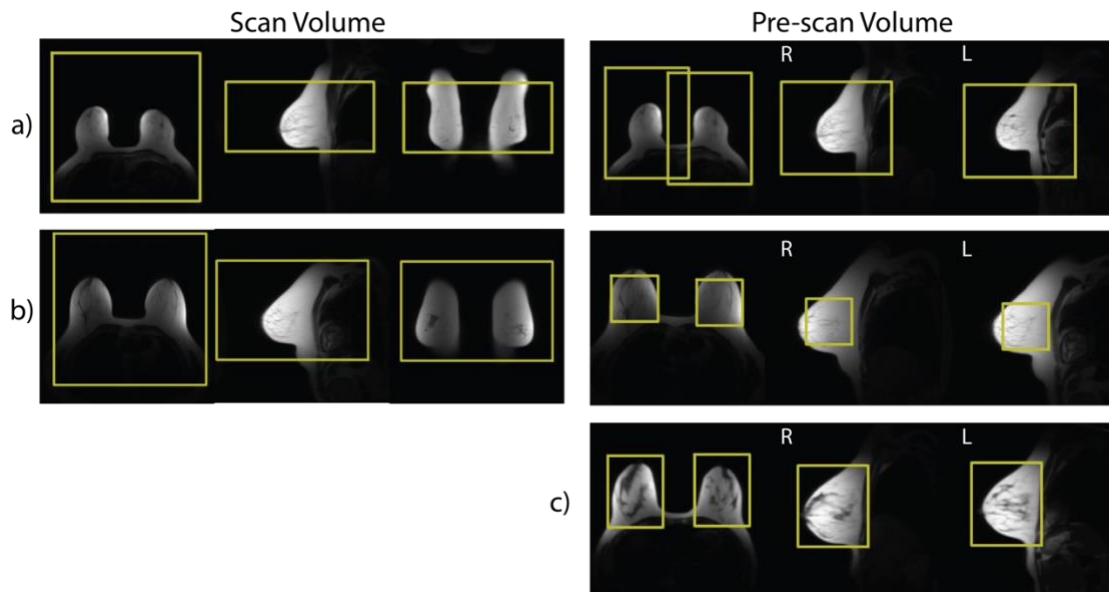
Example of Clinical Scan and Pre-scan Volumes in Breast MRI. Examples a) and b) show scan volumes and pre-scan volumes as prescribed during clinical breast MRI. Note that the placement of scan volumes was consistent across cases. However, the pre-scan volume placement was found to vary dramatically between cases even when the underlying anatomy is similar as is the case in a) and b). Example c) shows an example of offline volumes generated by expert users used to train pre-scan volume placement providing more consistent technique.
